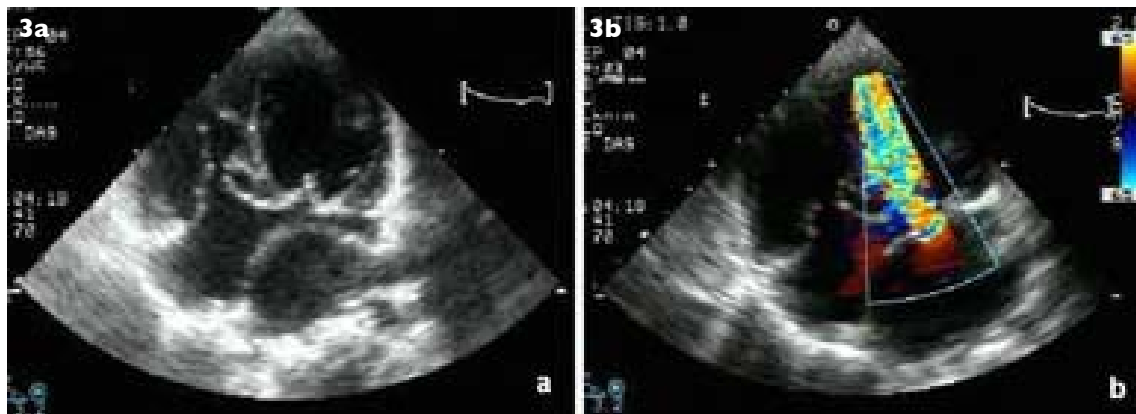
Transthoracic echocardiographical (a) apical four chamber image shows the defects and (b) colour Doppler image shows turbulent flow across the fenestration of the intra-atrial membrane.
